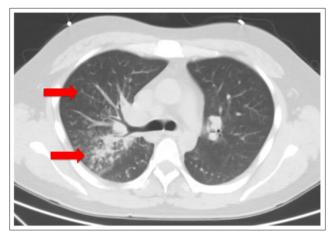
CT Chest with/without contrast – Transverse section
